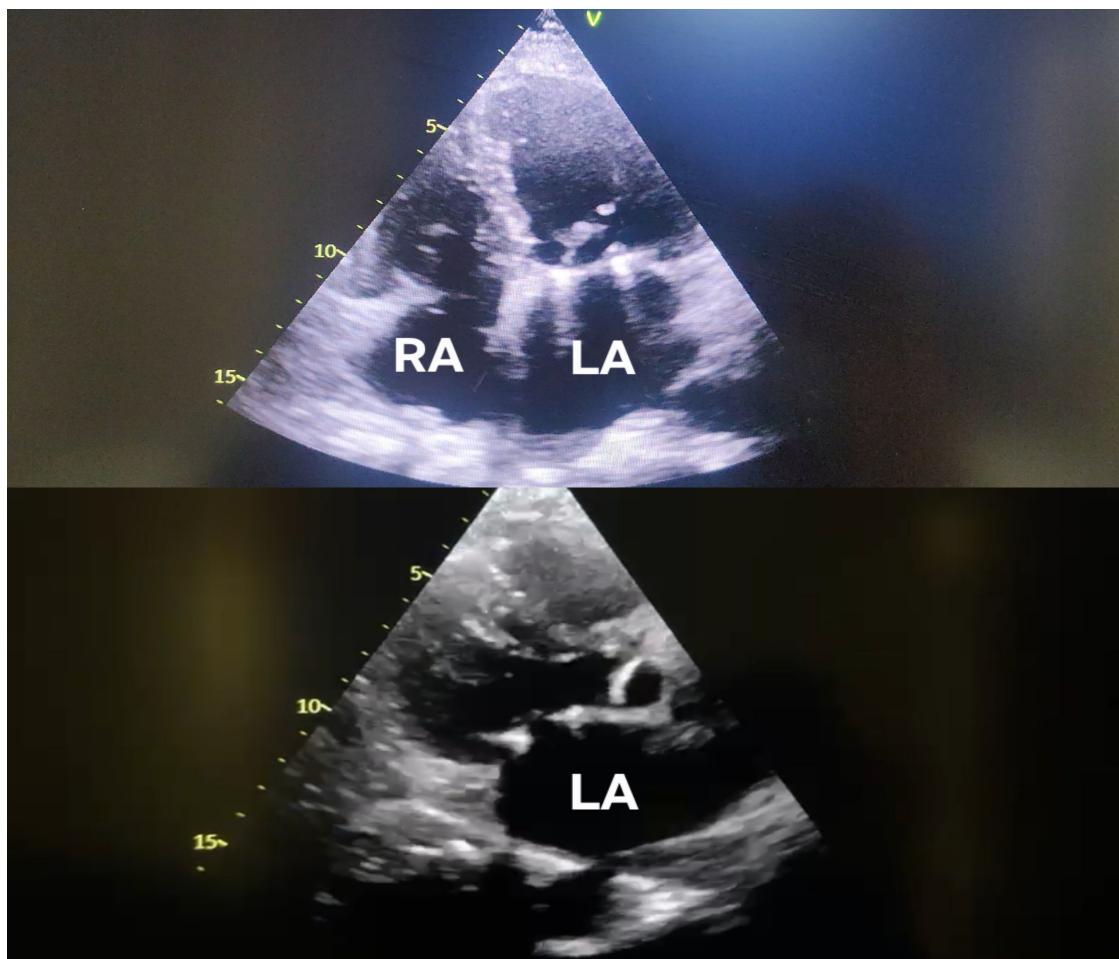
Transthoracic echocardiographic images one month after operation. LA = Left atrium; RA = Right atrium.
